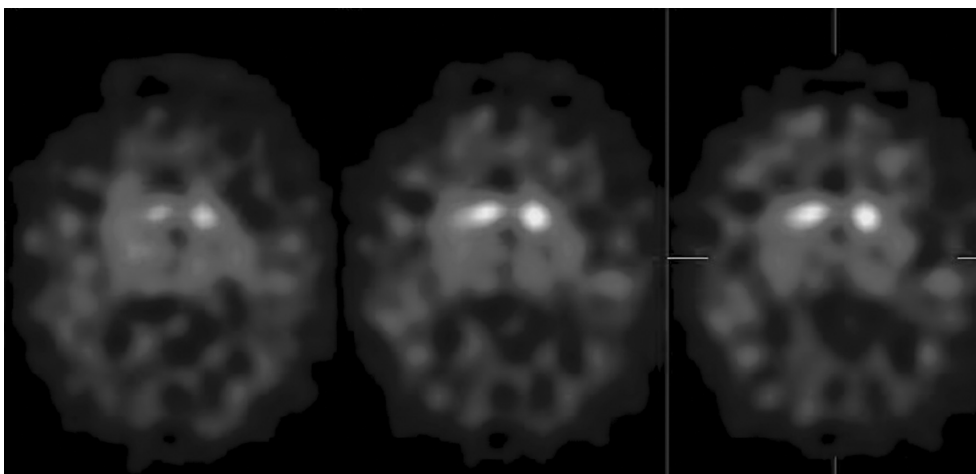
Functional imaging of the dopamine transporter by 123I-FP-CIT SPECT showing reduced striatal uptake in a patient affected by dementia with Lewy bodies. (Courtesy: Drs Andrea Varrone and Sabina Pappatà, Institute of Biostructure and Bioimaging, CNR, Naples.) (See color plate section.)
